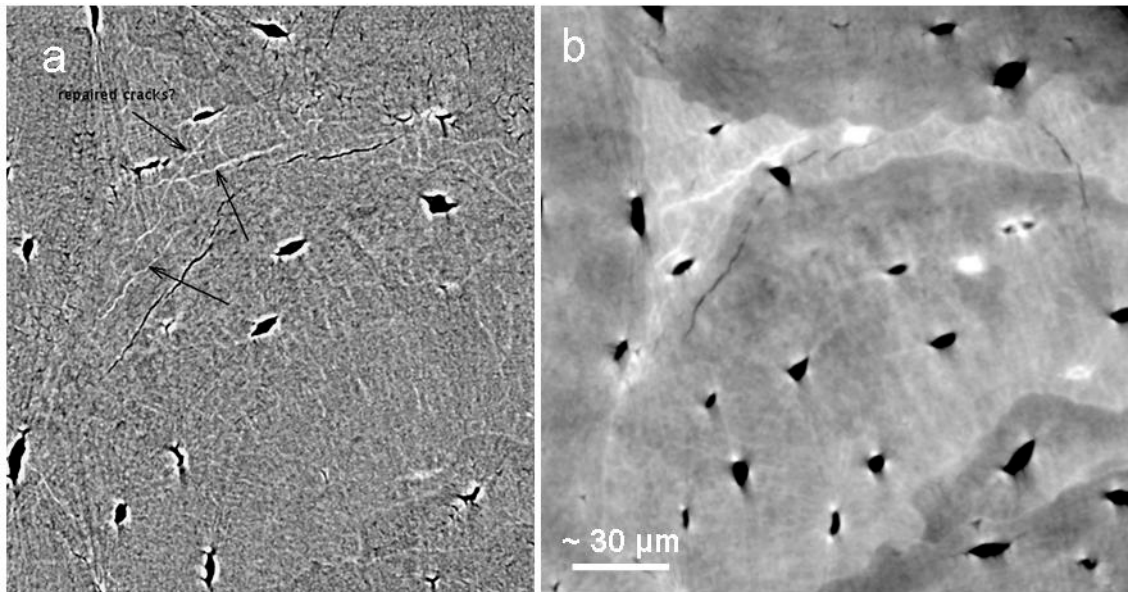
Regions from reconstructed slices showing mineralized micro-cracks located in interstitial tissue. a) Image reconstructed from X-ray attenuation combined with phase contrast b) Image reconstructed after phase retrieval. Image spatial resolution was 280 nm.
